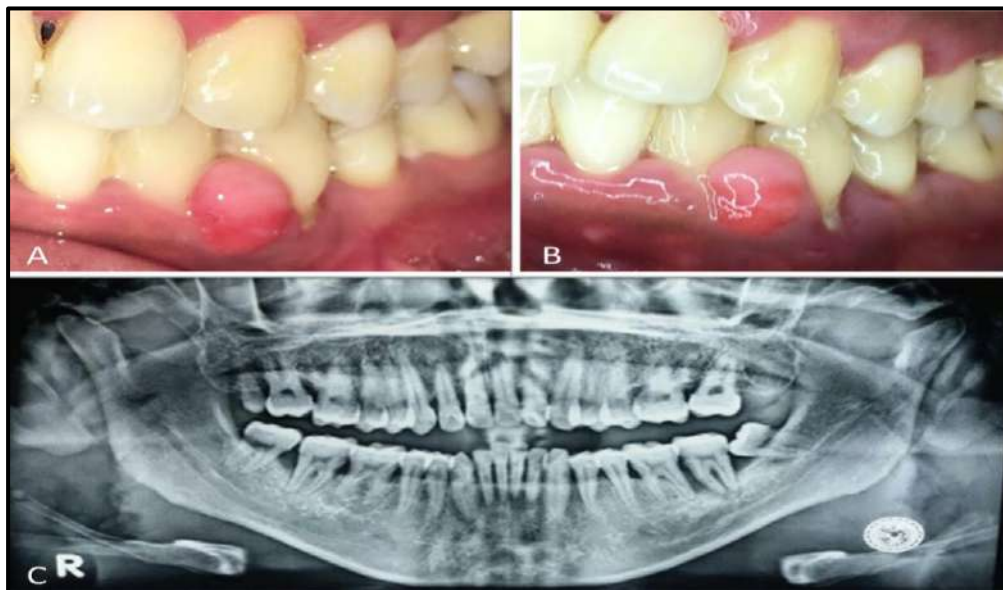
A. Clinical appearance at the first time. B. Clinical appearance after initial phase. C. Radiographic picture shows no bone loss around the mass.
